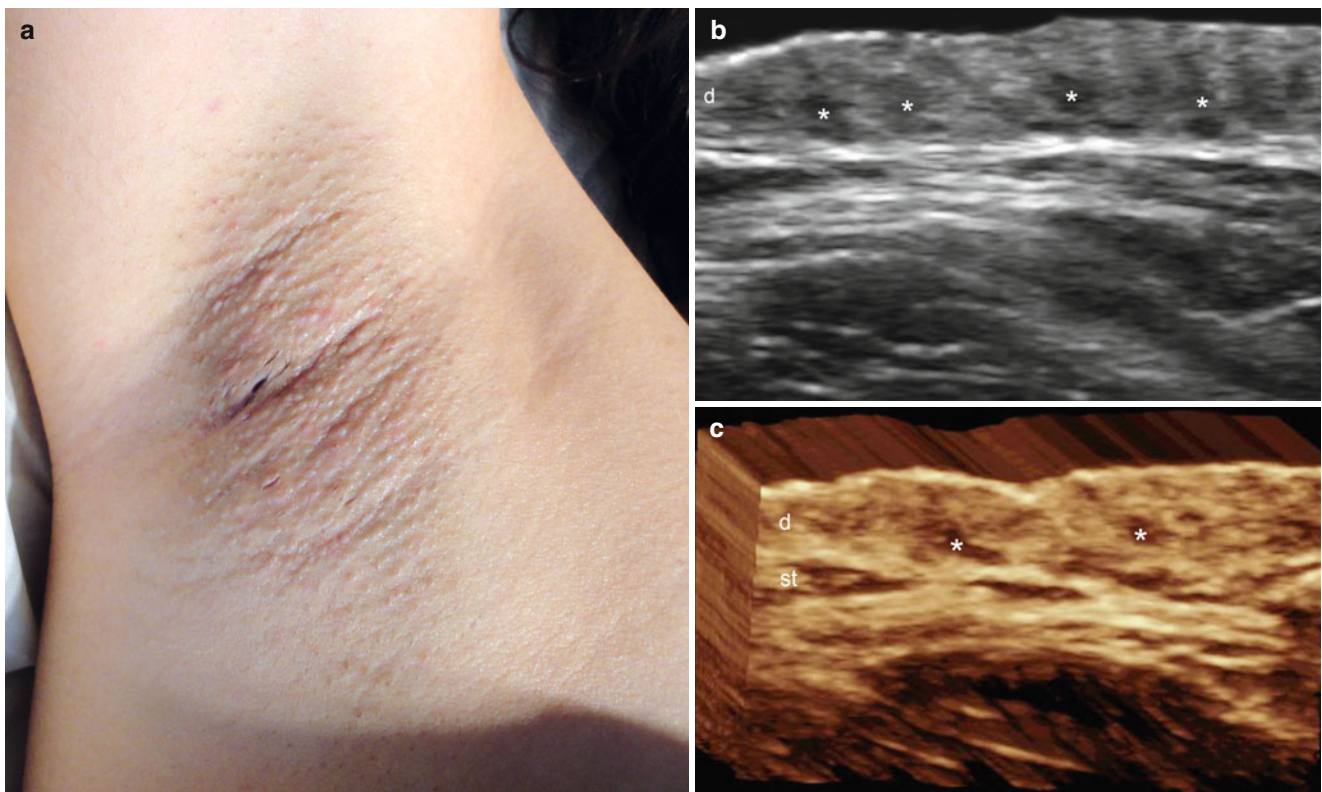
(a–c) Hidradenitis suppurativa. (a) Clinical image shows erythema in the right axilla (Hurley I). (b) Gray scale ultrasound image (transverse view) demonstrates enlargement of the base of the hair
